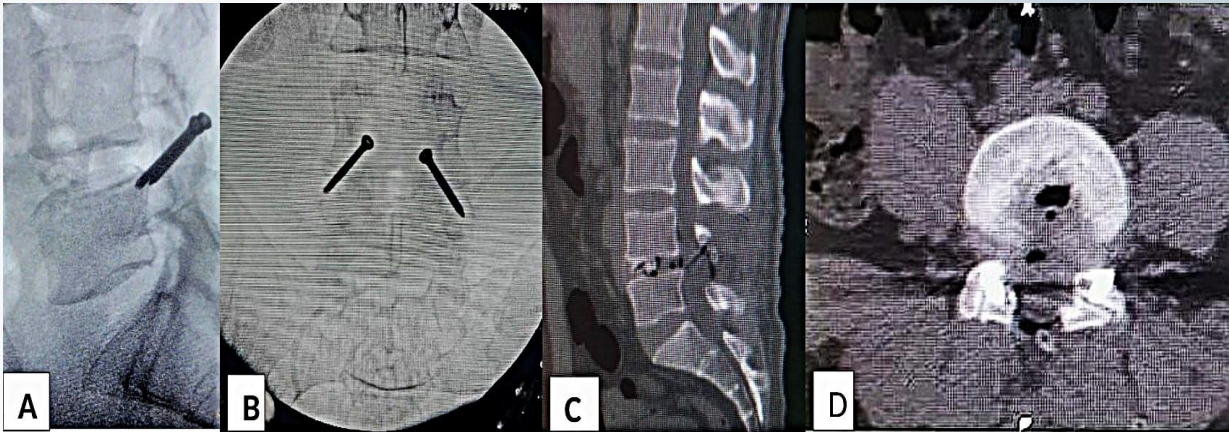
Intraoperative and postoperative images. A: Lateral lumbar fluoroscopic intraoperative image showing L4/5 transfacet screw fixation. B. Antero-posterior lumbar fluoroscopic image showing L4/5 transfacet screw fixation. C. Sagittal lumbar CT scan, bone window showing L4/5 transfacet screw fixation and interbody fusion.: D. Axial lumbar CT scan demonstrating L4/L5 transfacet screw fixation.
